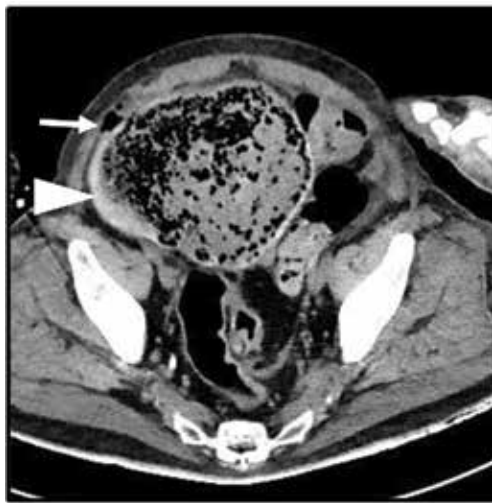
(A and B) Sagittal and axial non-contrast CT images of a patient with severe abdominal distention and constipation show a dilated colon with a large volume of feces and concentric wall thickening (arrows), indicative of stercoral colitis. (C and D) The majority of the fecaloma was removed in a piecemeal fashion with irrigation and retrieval devices. Images from the colonoscopy show friable, dusky, and erythematous mucosa (arrows), consistent with stercoral colitis and ischemia.
